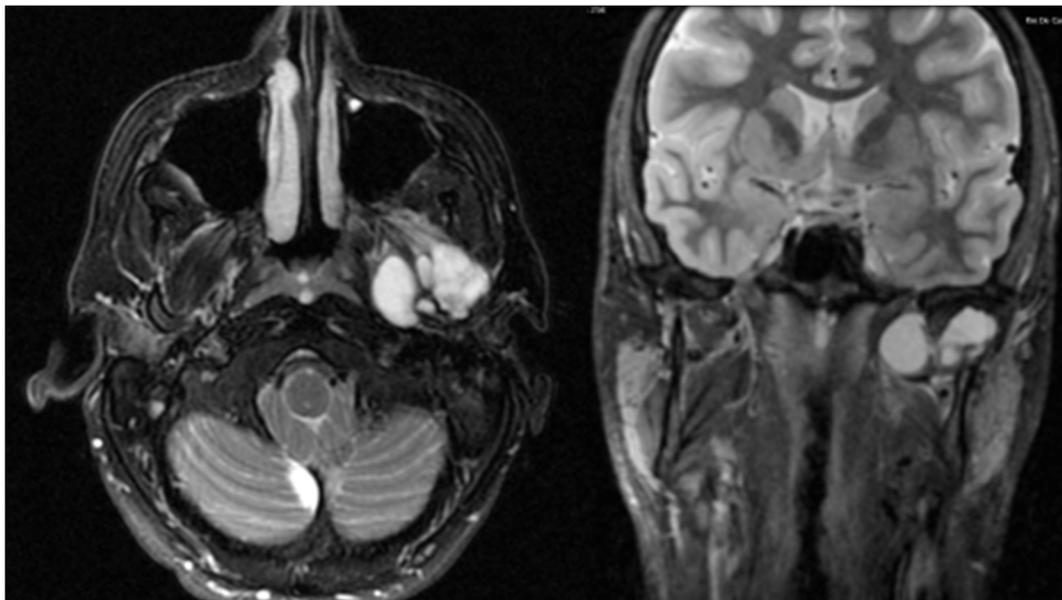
MRI of the patient before surgery. Hyperintense multilobular image on the left condyle.
